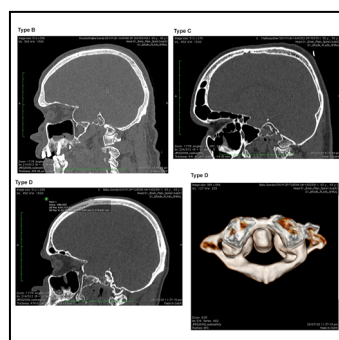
CT scan of individuals presenting Type B, C & D variety of ponticulus posterior.
